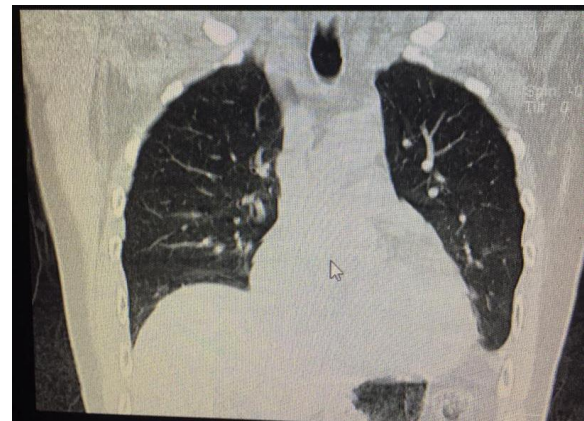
Lung computed tomography shows no evidence of active COVID-19 infection.
